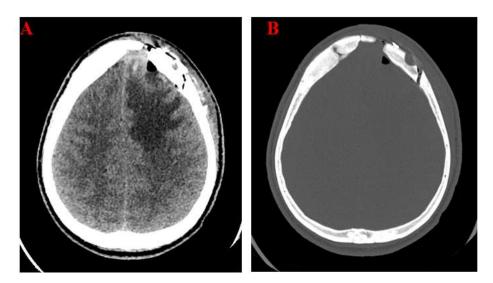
postsurgical Computed Tomography (CT) scan: (A) brain window showing postoperative changes with removal of the abscess, (B) bone window showing LT frontal craniotomy.
